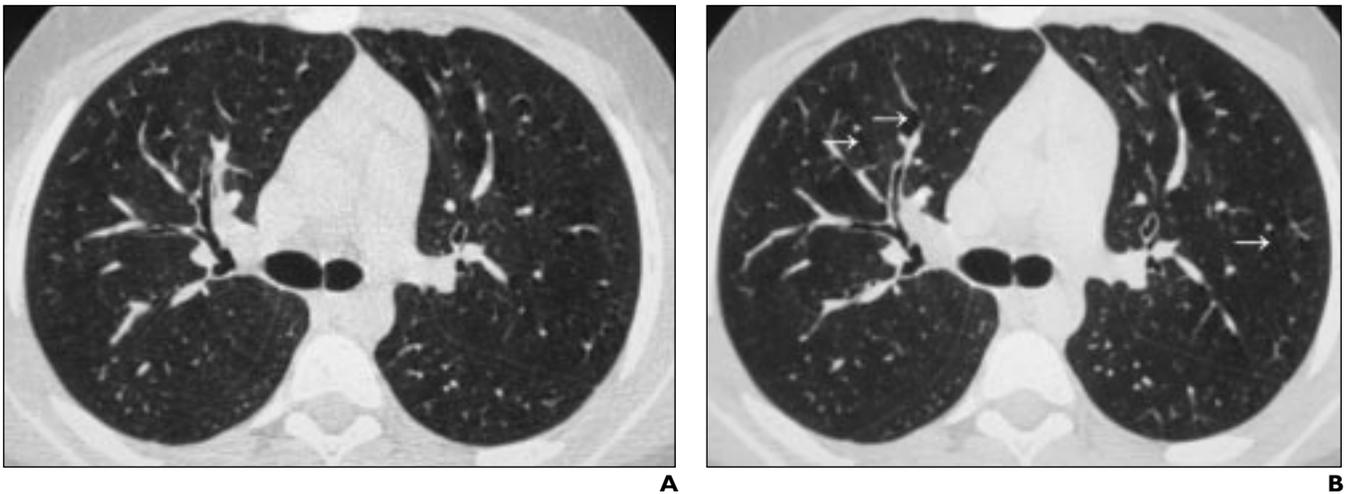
13-year-old boy who was examined to rule out bronchiectases. Images show normal findings. A, High-resolution CT scan of chest obtained with 34 mAs (average image quality score, 4.58) shows that depiction and sharpness of lung structures are good. Noise, best identified in low-contrast structures of mediastinum and chest wall, is more evident in this image than in B. B, High-resolution CT scan of chest obtained with 180 mAs (average image quality score, 4.50) shows several streak artifacts (*arrows*).
